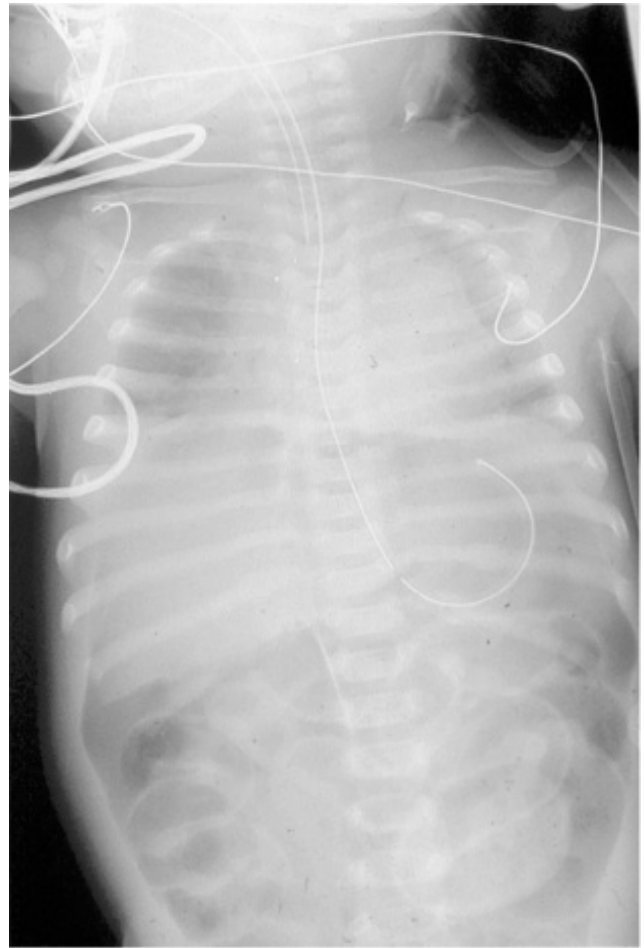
Flat abdominal radiograph demonstrating massive free intraperitoneal air. This was due to a jejunal perforation from a direct blow to the midabdomen.
